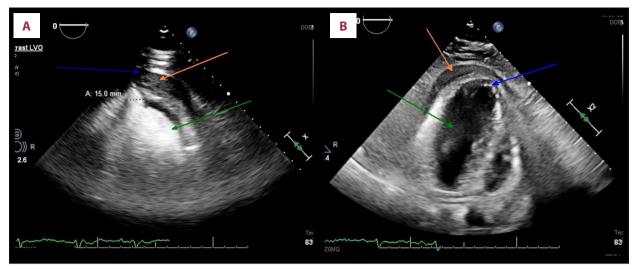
Apical 4-chamber view echocardiogram. Orange arrow showing pericardial effusion. Blue arrow showing aneurysmal segment with site of suspected contained rupture and neck of aneurysmal segment measurement. (A) Green arrow showing LV filled with contrast, (B) green arrow showing LV without contrast.
